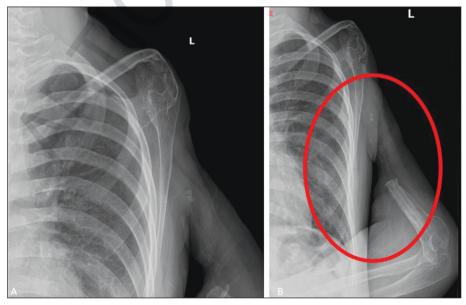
Preoperative X-ray images of the patient at admission.
